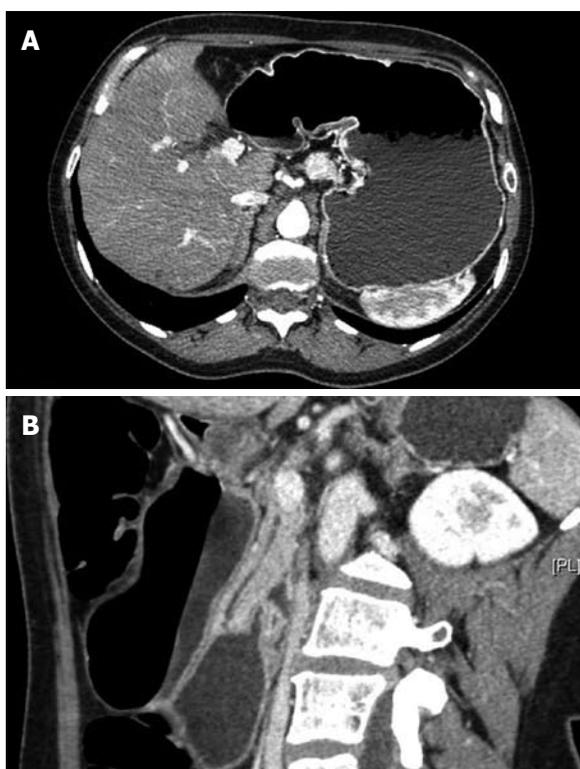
The communication of the 2 cavities visualized by computed tomography. A: Frontal view; B: Lateral view.
